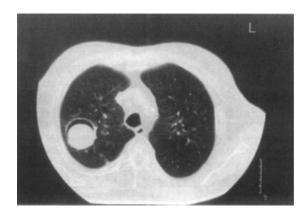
CT scan (single cut) of the upper thorax of patient MS showing a textbook example of an air crescent so typical of an aspergilloma, but without any pleural thickening, which is unusual for an aspergilloma, September 1998.
